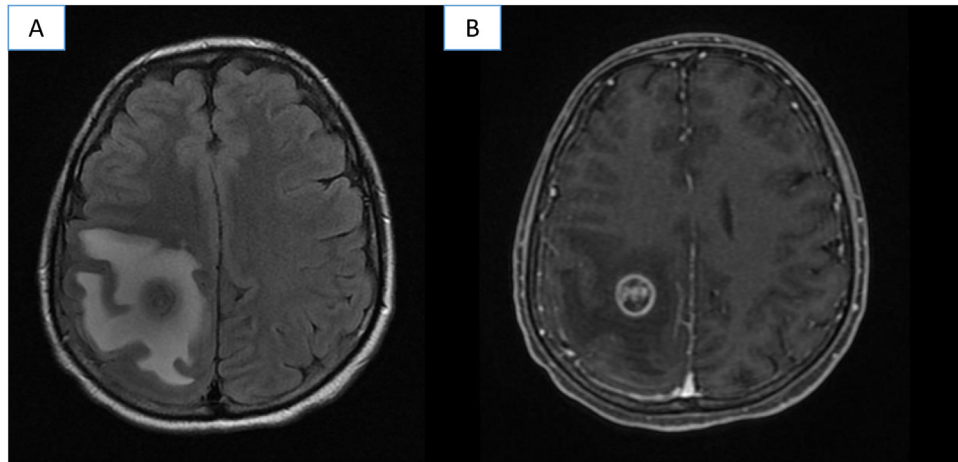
MRI with right frontoparietal lesion with perilesional edema: A. T2 FLAIR sequence B. With gadolinium.
